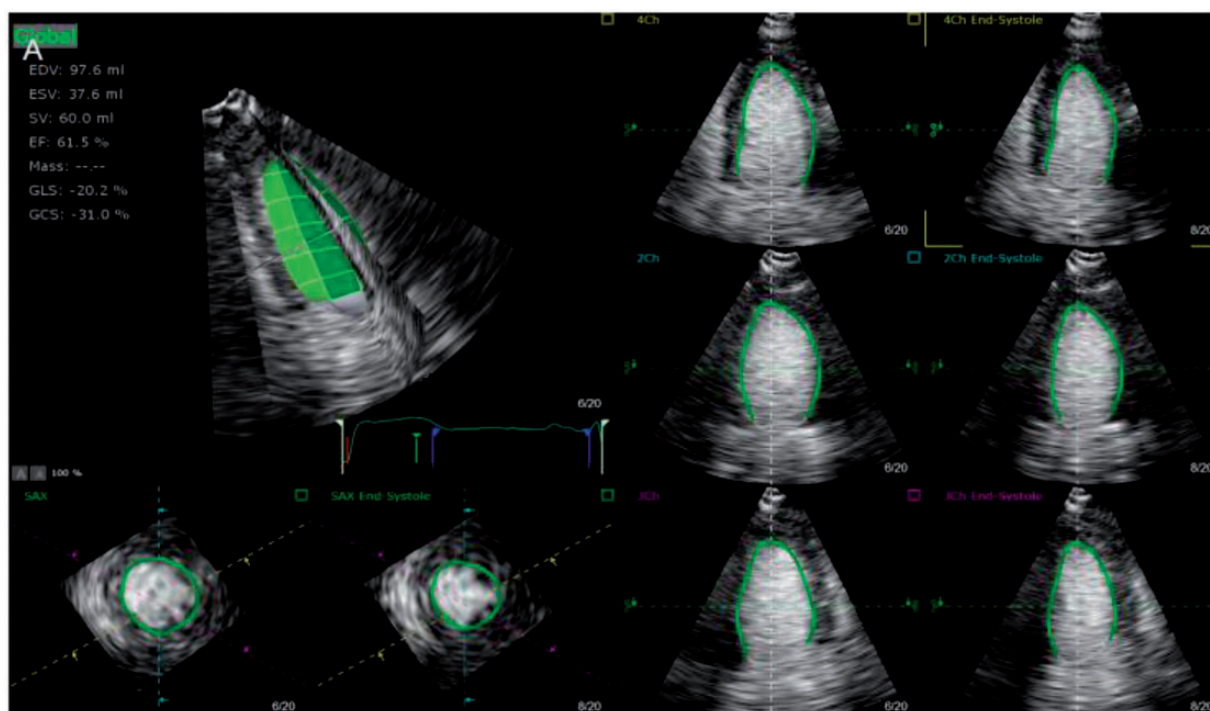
Orthogonal slices obtained from a full-volume data set recorded with 3D contrast echocardiography.
